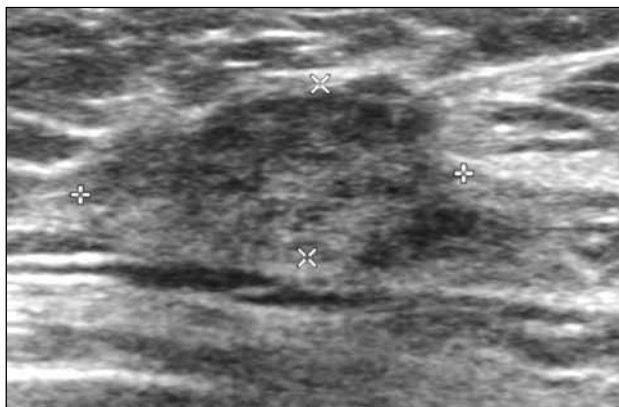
Ultrasonogram of a 71-year-old woman with known lymphoma presenting with palpable right breast mass. An irregular mass with heterogeneous echogenicity with echogenic component is evident at the outer part of the right breast. It has obscured margins. Biopsy confirmed lymphoma involvement.
